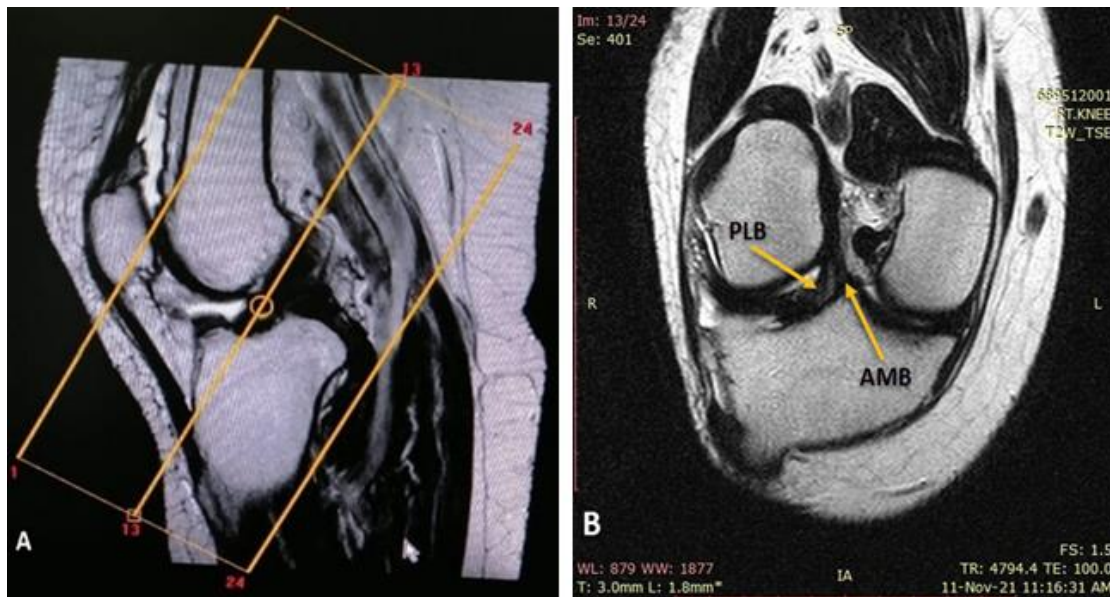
Demonstrating the technique used to obtain T2W- coronal oblique MRI image of normal ACL. A) Sagittal T2 image used to obtain B) T2W- coronal oblique image by superimposing 3 mm slice thickness with 0.3 mm gap interval on it in a plane parallel to the Blumensaat's line "which is the line drawn along the roof of the intercondylar notch of the femur on a sagittal view of the knee" along the course of the ACL with relaxed knee and slightly externally rotated (about 10-15 degrees).
